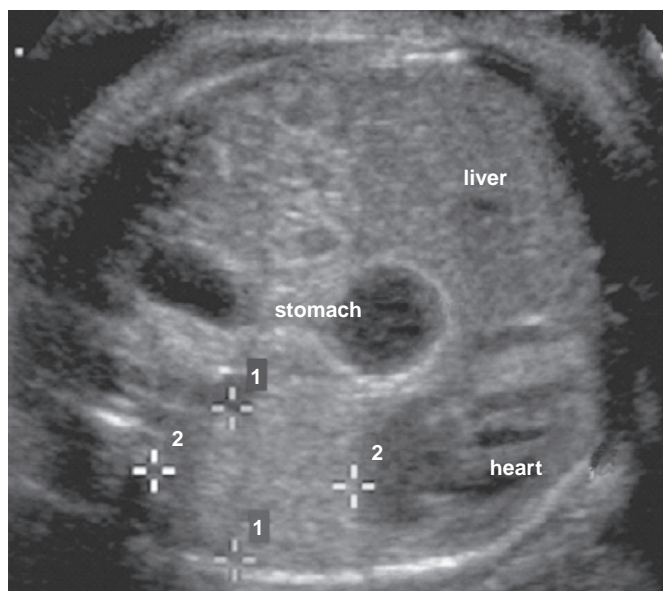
Transaxial ultrasonographic image of the chest in a fetus with a left diaphragmatic hernia (liver, stomach, and heart labeled). Measurements of the right lung (1 and 2) are made using electronic calipers to calculate the LHR.
